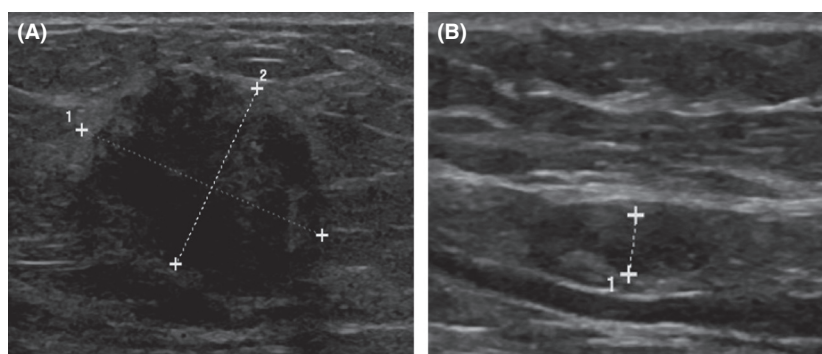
Ultrasound images. (A) Right breast: there is an irregular hypoechoic mass corresponding with the palpable and mammographic lesion and measuring 20 × 15 mm in the upper outer quadrant. (B) Right axilla: an abnormal lymph node with focal cortical thickening (4 mm) is noted. Ultrasound guided core biopsy: grade 3 invasive ductal carcinoma, ER, PR and HER2 receptor negative. FNA of the node was positive for metastasis. Patient underwent wide local excision and axillary clearance, egg harvesting to preserve fertility followed by chemotherapy and bilateral mastectomy with immediate reconstruction.
